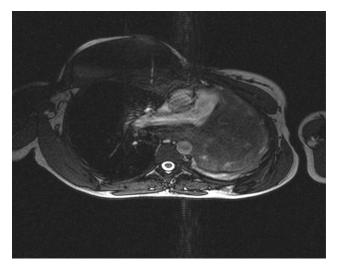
MRI at 14 weeks of amenorrhea of the 1<sup>st</sup> pregnancy showing HL with left lung involvement, mediastinal extension with right pleural-pulmonary determination and extension to the anterior right ribs.
